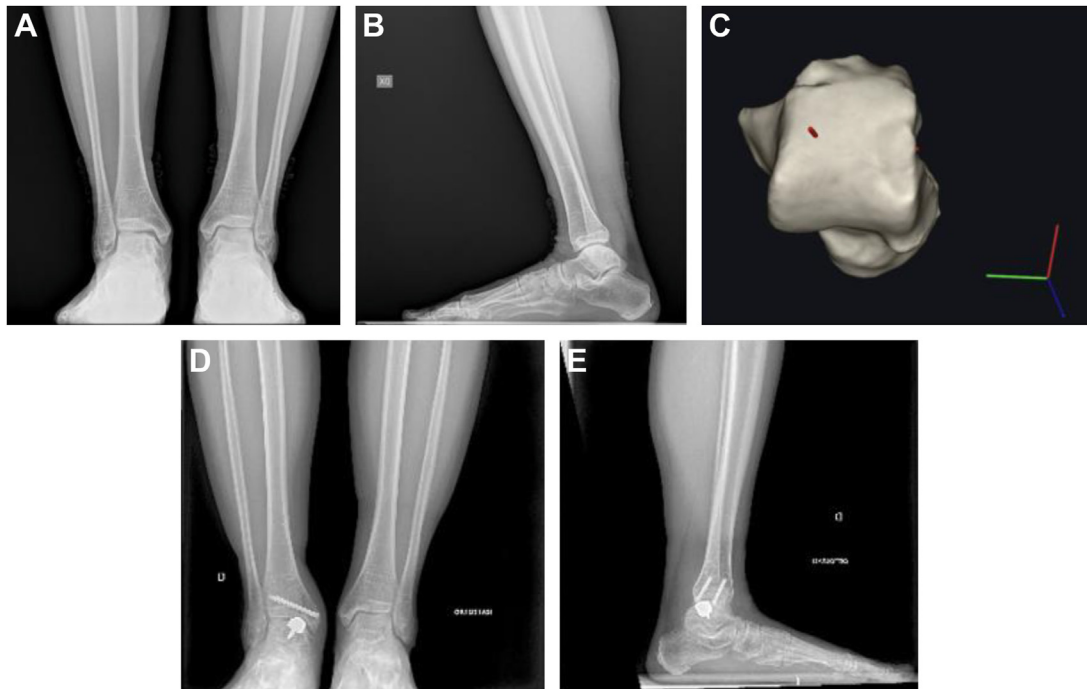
(A) Preoperative weight-bearing X-rays in an anteroposterior (AP) view showing a medial side osteochondral lesion. (B) Preoperative weight-bearing X-rays in lateral view showing an osteochondral lesion. (C) Preoperative weight-bearing computed tomography (CT) showing medial osteochondral lesion. (D) Sixteen months postoperative weight-bearing X-ray in an AP view showing an Episurf metal implant. (E) Postoperative 16-month follow-up weight-bearing X rays in lateral view showing an Episurf implant.
